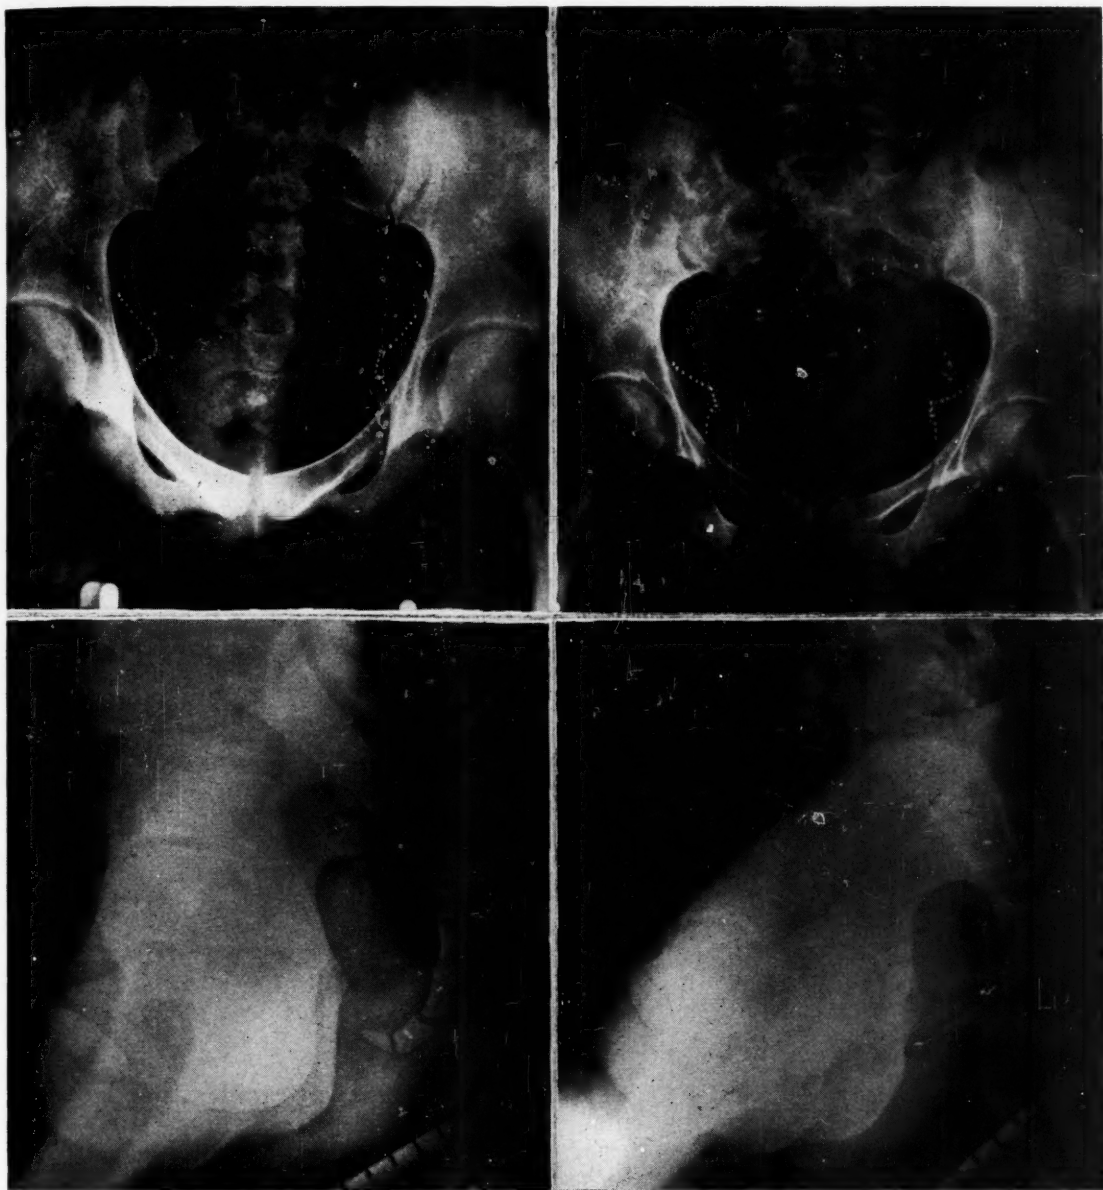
X-ray pelvimetry in Cases 10 and 6. On the left, an android-anthropoid pelvis of poor obstetrical type is demonstrated. On the right, a gynecoid pelvis with an anthropoid outlet and straight sacrum is shown.
